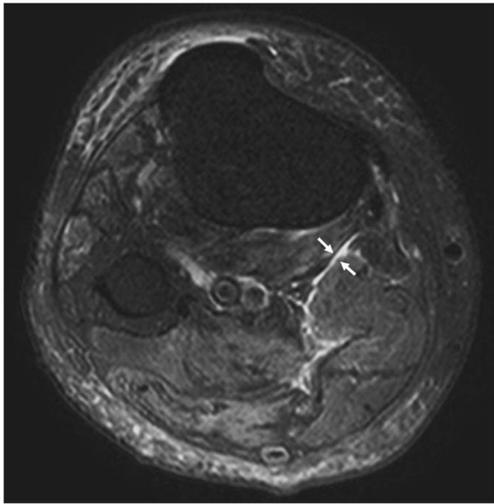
A 65-year-old female with cellulitis with non-necrotizing fasciitis. Axial fat-suppressed T2-weighted image of the right lower leg demonstrates the absence of thickening of the intermuscular deep fascia or multi-compartmental involvement. The LRINEC score was 4. Total score using the new score system was 4 (thickening of intermuscular deep fascia ≥ 3 mm [0 point] + multi-compartmental involvement [0 point] + LRINEC score [4 points]) with a predicted probability of 20.7% for necrotizing fasciitis
